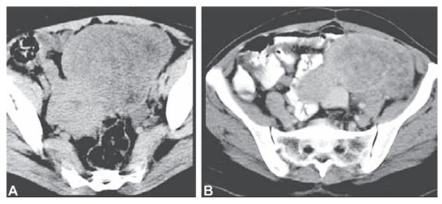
Contrast enhanced CT pelvis images show a cervix mass with internal calcification in the region of cervix was confirmed as cervical fibroid
